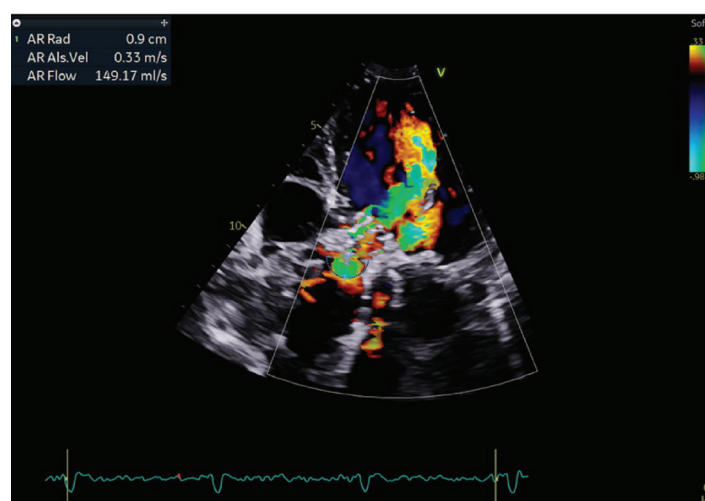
Severe intravalvular aortic regurgitation (transthoracic echocardiography).
